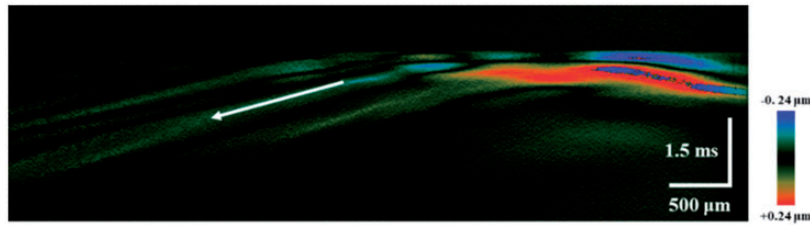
Spatiotemporal Doppler OCT image of *ex vivo* healthy rabbit cornea at a selected depth. The direction of wave propagation is depicted by a white arrow. (A color version of this figure is available in the online journal.)
